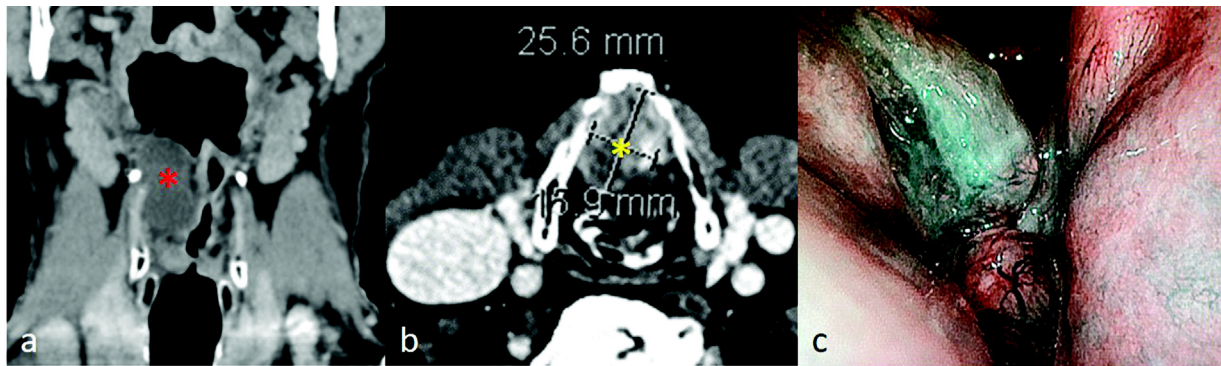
Six months after surgery: computed tomography coronal scan.
